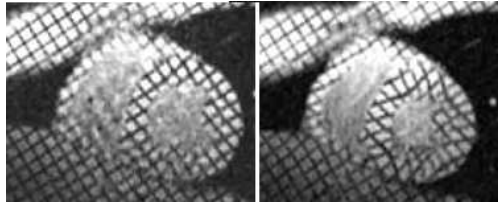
Cine tagged-MRI of the heart
